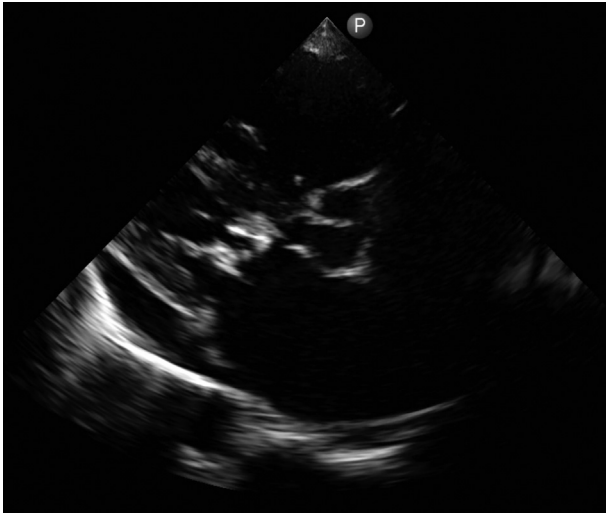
Parasternal long-axis view by two-dimensional transthoracic echocardiography showing restriction of the anterior and posterior mitral leaflets at end-diastole. The left atrium and right ventricle are both noted to be significantly dilated. There is a small pericardial effusion.
